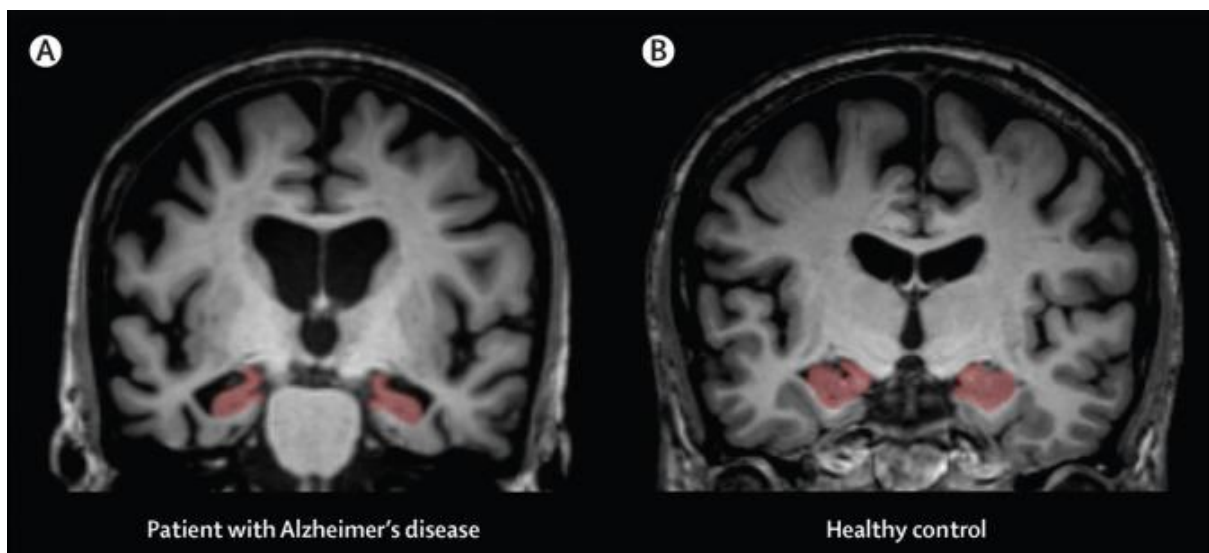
Coronal sections shown from high-resolution structural MRI scans depicting the head of the hippocampus (labelled in red) in a patient with Alzheimer's disease (A) and a healthy age-matched control (B). Severe atrophy of the hippocampus in the patient with Alzheimer's disease is evident by visual comparison with the healthy control (Teipel, Drzezga, Grothe, Barthel, Chetelat, Schuff et al., 2015)
